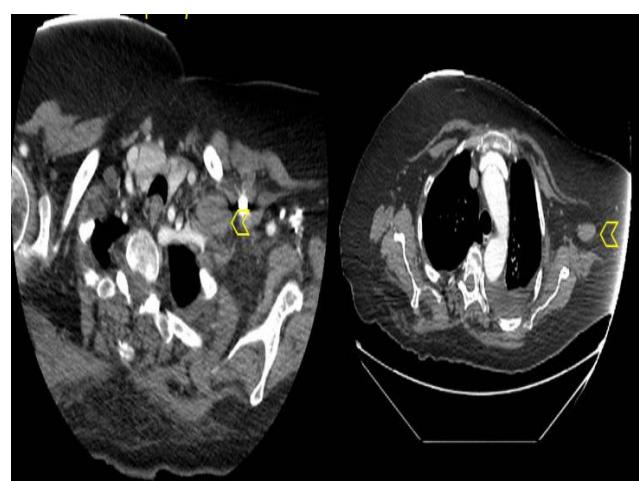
Axial CT Thorax showing left supraclavicular and axillary adenopathy.
